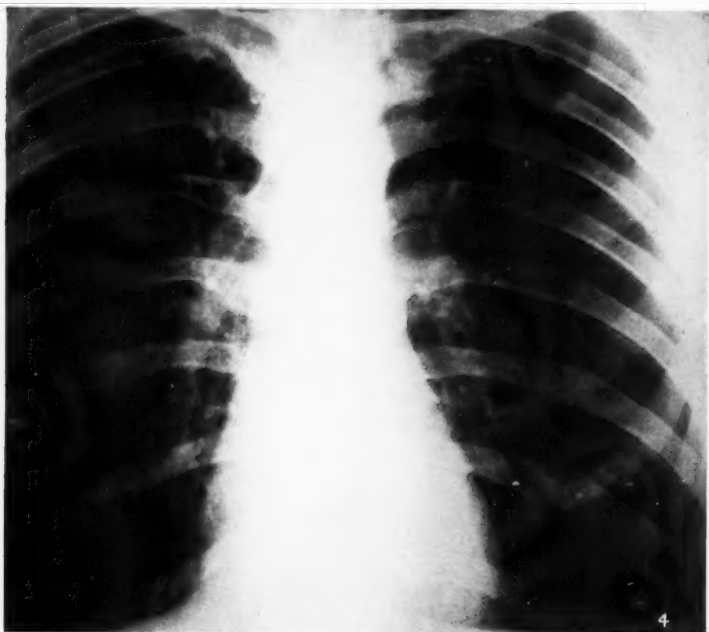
(Case 3.) On discharge 6 weeks later X-ray chest showing recovery.
